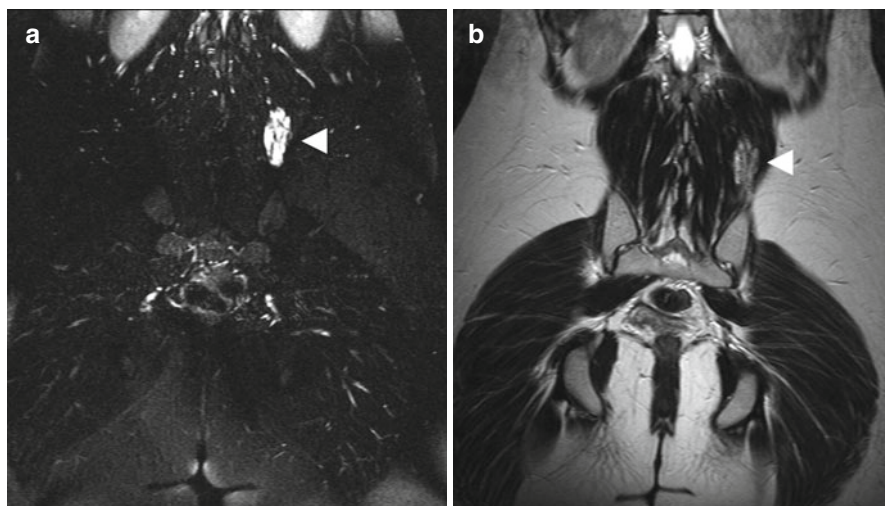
Incidental screening finding (STIR) and diagnostic workup. Twenty-two-year-old female subject with a sharply demarcated lesion of high signal intensity (*arrowhead*) in the back muscles on the left (a). Diagnostic workup including an additional MRI examination with IV contrast medium administration confirmed the suspected asymptomatic intramuscular hemangioma. The lesion has high signal intensity on coronal T2w TSE image (b); is isointense to muscle on coronal T1w TSE image (c); and shows strong enhancement on fat-suppressed contrast-enhanced coronal T1w TSE image (d)
